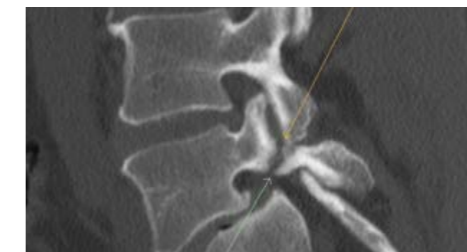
CT sagittal reformat. Complete L5 pars stress fracture with non union.
